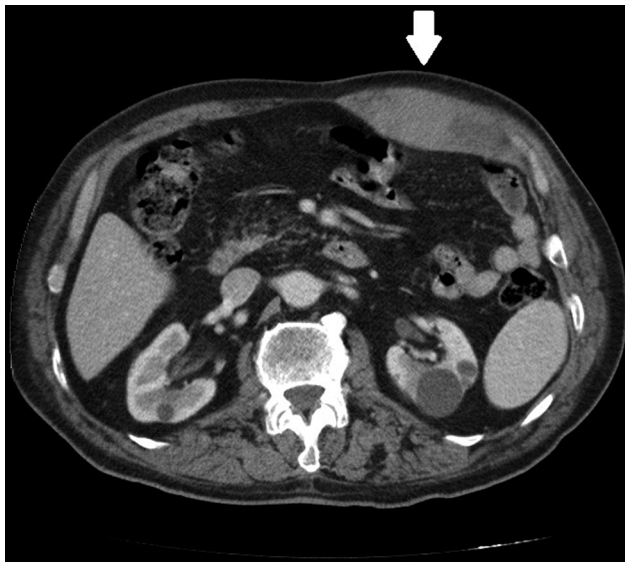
Contrast-enhanced abdominal computed tomography finding of left rectus sheath hematoma (arrow).
